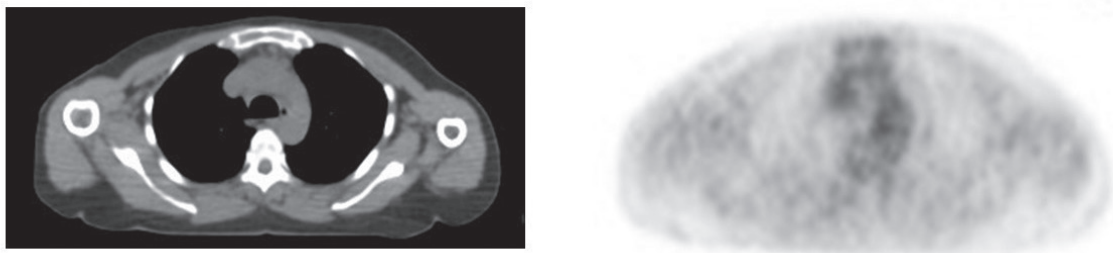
Anterior mediastinal lymph nodes were detected with no 18-FDG intake.
